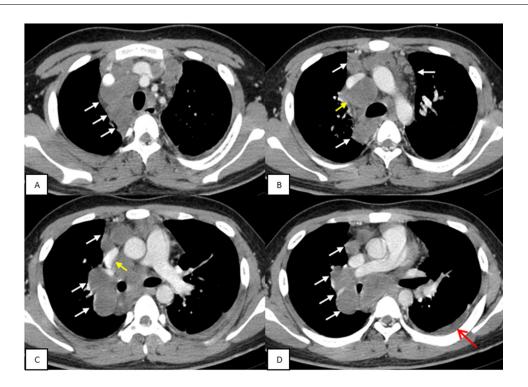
CT chest, mediastinal window after intravenous contrast injection (slices from top to bottom).
